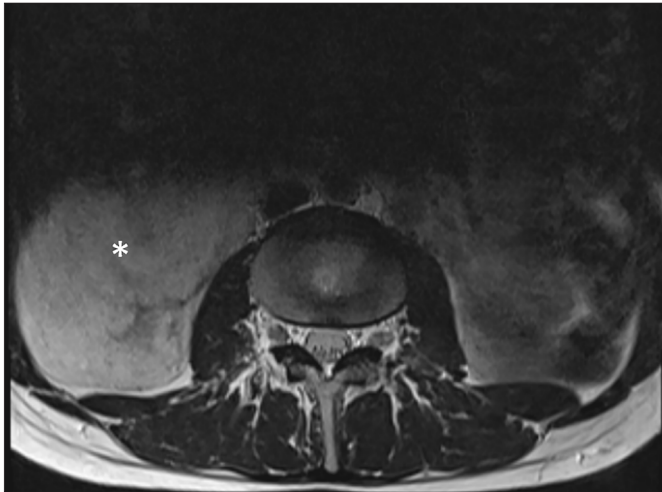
Hyperintense mass appearance of a giant angiomyolipoma in the right kidney (asterisk) in T2-weighted axial images in lumbar spinal MRI examination.
